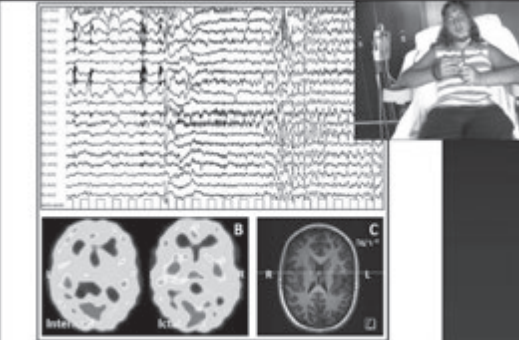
Atrial EEG recording of an eating-induced seizure characterized by head drop, impaired consciousness, and manual muscle behavior of right hand. The EEG shows diffuse flattening, increasing biphasic fast rhythms, followed by diffuse slow waves interspersed with spike waves with maximum under the right posterior central area (A). PET studies show interictal right side hypermetabolism and focal lateral temporal hypermetabolism (B). Brain MRI reveals a left peritrigonal polymicrogyria (C).
